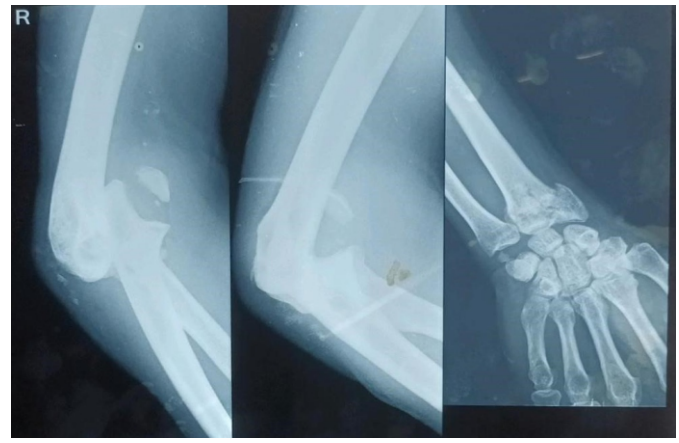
X-ray showing anterior elbow dislocation with fracture medial epicondyle and fracture distal radius.
